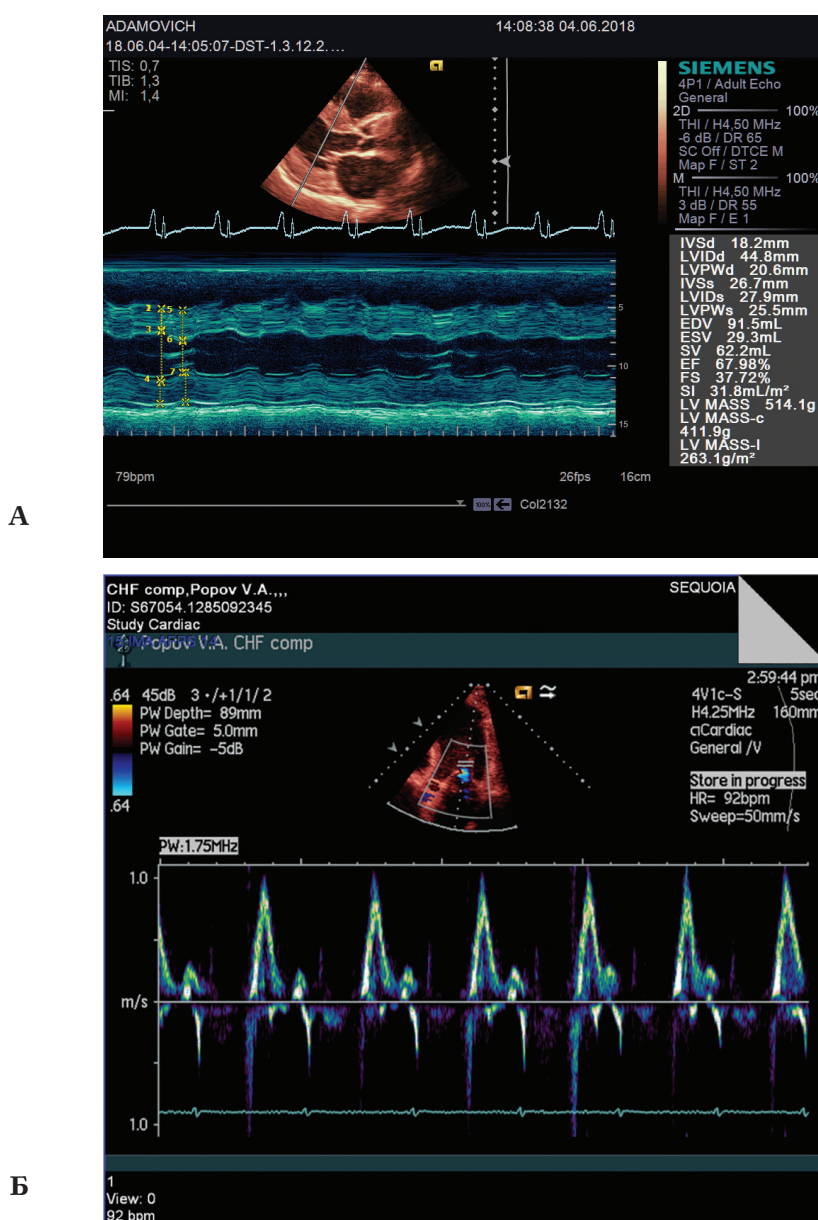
Transthoracic echocardiography of a patient with cardiac amyloidosis. In the upper part, there is a thickening of the walls of the left ventricle, B-mode, apical four-chambered position. In the lower part, restrictive type of diastolic dysfunction, transmitral flow, pulse wave Doppler (photos from the archive Dr Reznik E.V.)
